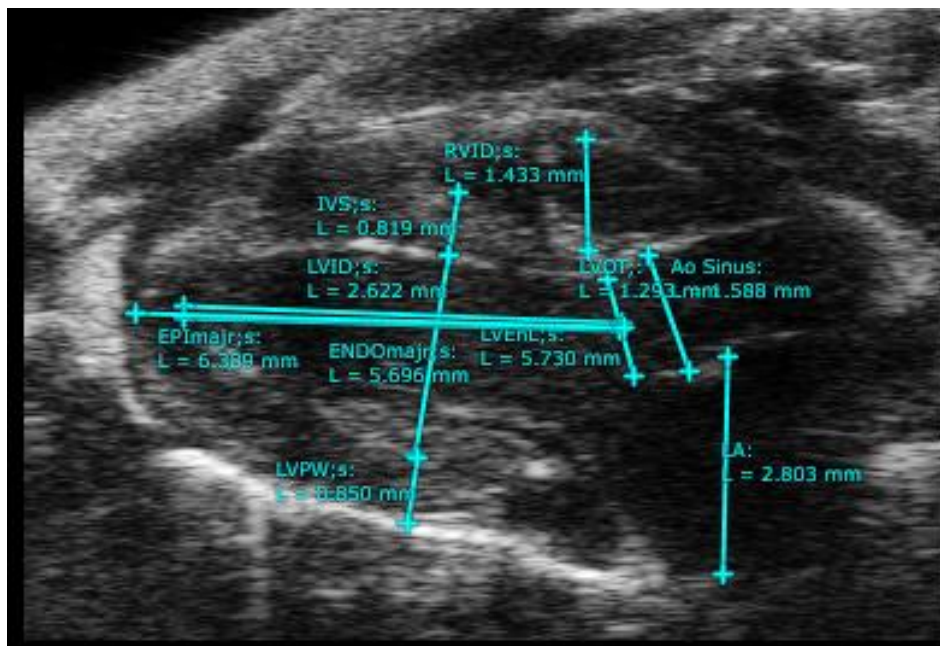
Parasternal long axis view in Systole with measurements of Left ventricular (LV) length, septal (IVSs) and posterior wall thickness (LVPWs) and LV internal systolic dimension (LVIDs).
